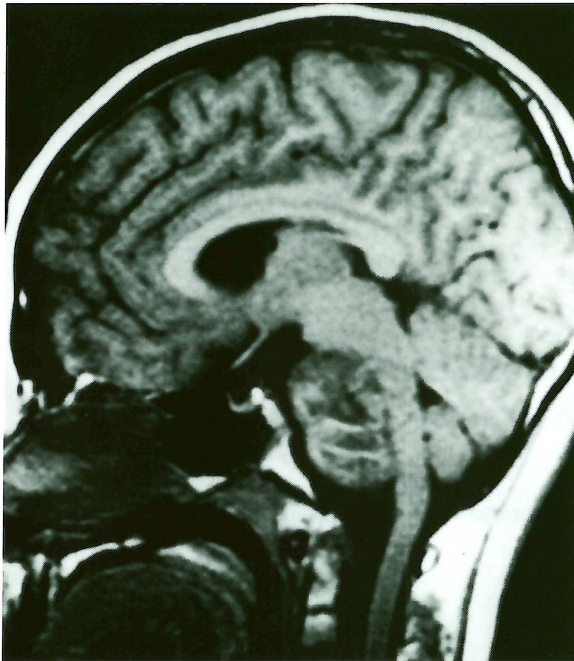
Case 1. MRI (T1 weighted) shows a giant mass in front of the brain stem.
